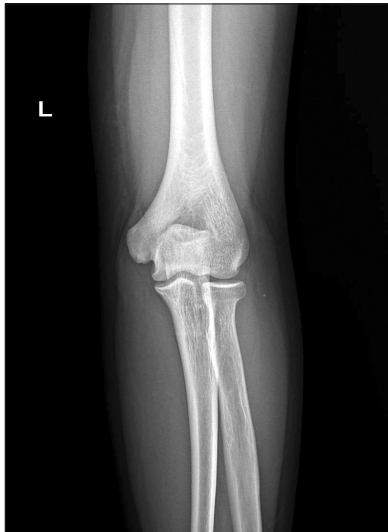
Lucencies of trochlea OCD demonstrated on plain radiograph.
